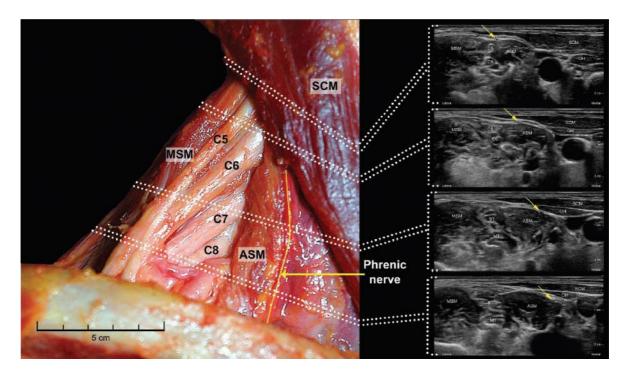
Cadaveric (left) and sonographic (right) images showing the course of the phrenic nerve.
